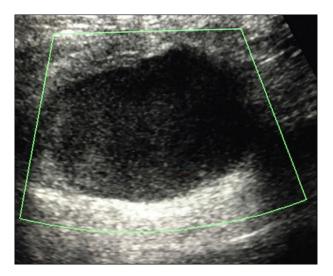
Ultrasonographic control in Doppler mode, performed soon after an injection of thrombin, to ensure the persistence of pseudoaneurysm thrombosis, as well as a patency of the artery that originated it. Hyperechoic image within the pseudoaneurysm corresponding to the group formed by thrombin injection (red *arrows*).
